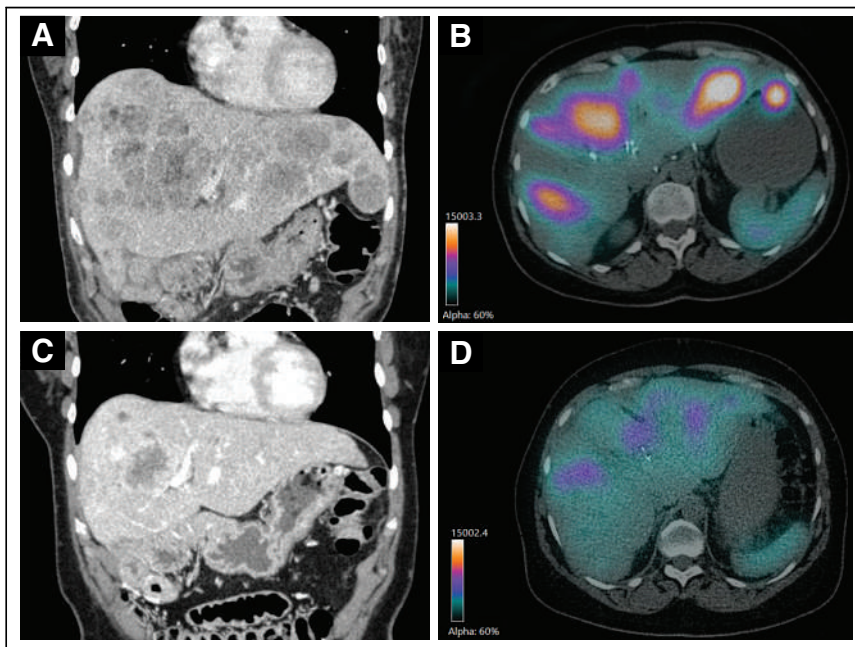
62-y-old female patient who received 3 [^{90}Y]Y-DOTATOC and 1 [^{177}Lu]Lu-DOTATOC therapy cycles (total activity, 26.7 GBq) and benefited more than 15 of 18 mo of observation. Baseline CT scan (A) and intratherapeutic [^{90}Y]Y-DOTATOC SPECT/CT of second therapy cycle show multiple liver metastases (B). CT scan after second therapy cycle shows partial tumor response with significantly reduced tumor burden according to RECIST 1.1 (C). Intratherapeutic [^{90}Y]Y-DOTATOC SPECT/CT of fourth therapy cycle (D) shows reduced [^{90}Y]Y-DOTATOC uptake in liver metastases compared with [^{90}Y]Y-DOTATOC SPECT/CT of second therapy cycle (B), which also indicates treatment response.
